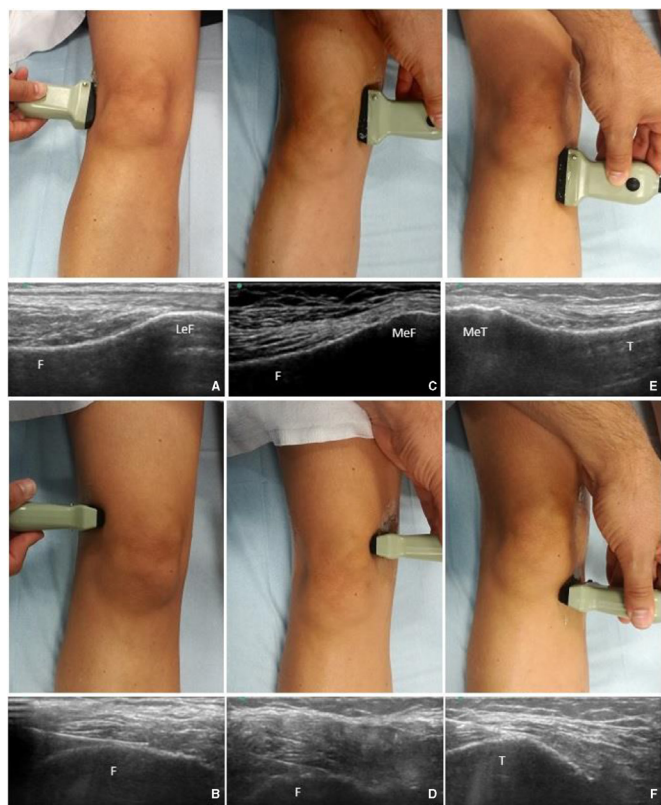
Probe positioning (in healthy volunteer) and ultrasound images (in cadaver) with the RF cannula in the final position. (A) target point for the SLGN in the coronal plane. (B) Final position of the RF cannula for the SLGN in the transverse plane. (C) Target point for the SMGN in the coronal plane. (D) Final position of the RF cannula for the SMGN in the transverse plane. (E) Target point for the IMGN in the coronal plane. (F) Final position of the RF cannula for the IMGN in the transverse plane. Left is proximal, right is distal (A,C,E); left is anterior, right is posterior (B,D,E). F, femur; IMGN, inferomedial genicular nerve; LeF, lateral epicondyle femur; MeF, medial epicondyle femur; MeT, medial epicondyle tibia; RF, radiofrequency; SLGN, superolateral genicular nerve; SMGN, superomedial genicular nerve; T, tibia.
